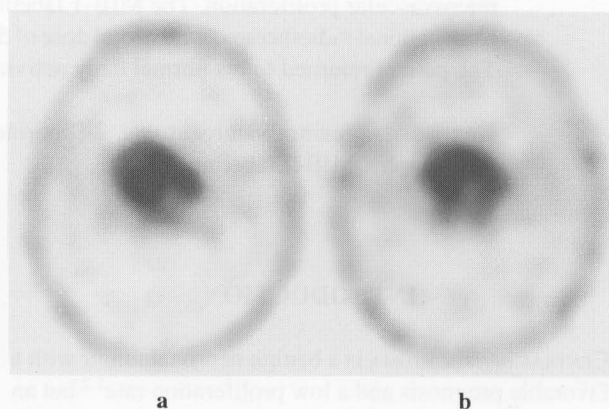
The transaxial images of ^{201}Tl SPECT. a) Early ^{201}Tl SPECT image showing intense tumor uptake in the right lateral ventricle. b) Delayed ^{201}Tl SPECT image showing slightly increased accumulation of the tumor compared to that of an early ^{201}Tl SPECT image.
